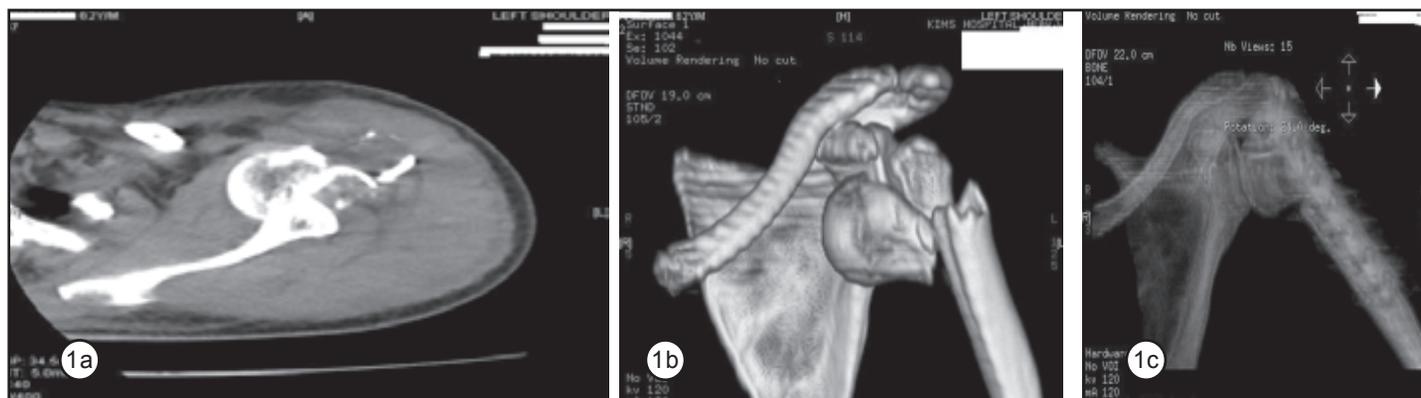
Pre-operative CT scan; Figure 1b: Pre-operative 3D CT scan; Figure 1c : Post-operative CT scan (Case 1)
